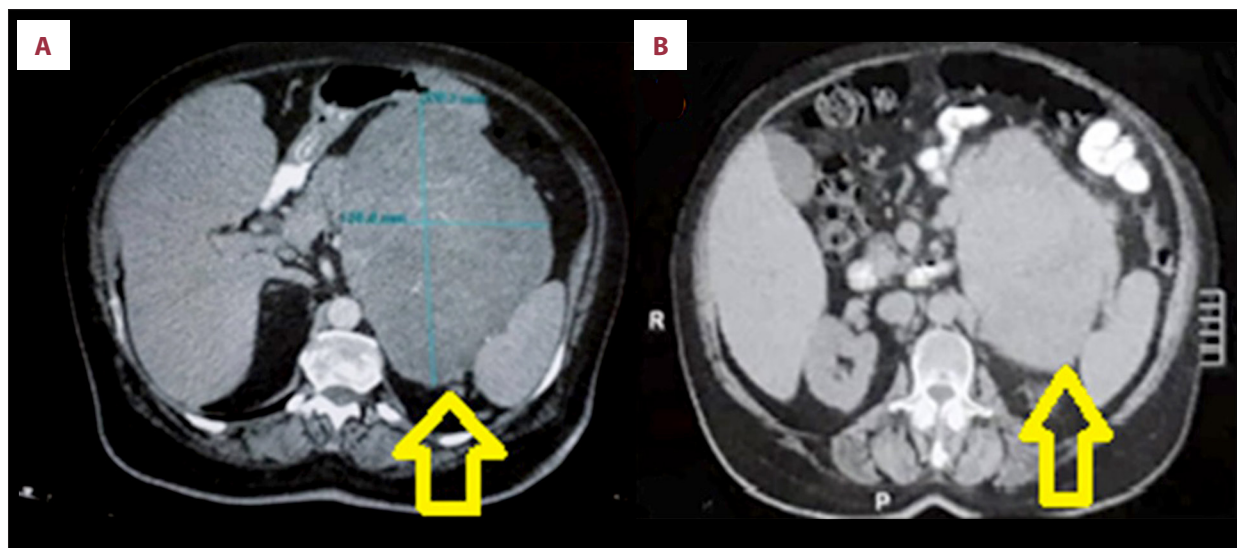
(A, B) CT scan with abdominal mass next to the left kidney.
